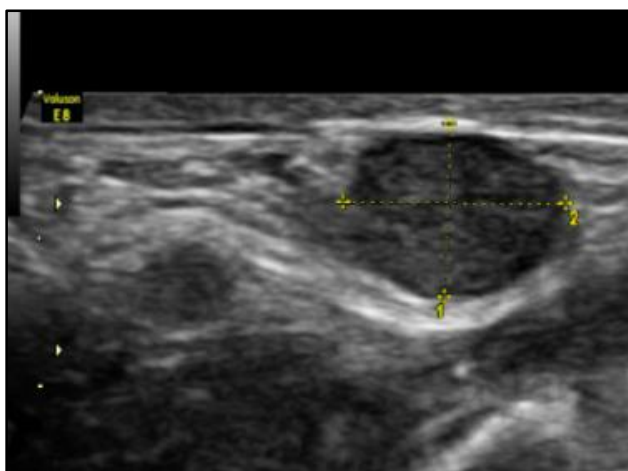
(a) Transverse B-mode sonogram of left level III cervical lymph node of a 55-year-old man showed score of 7, (b) Elastography showed pattern 4 (score 8).
